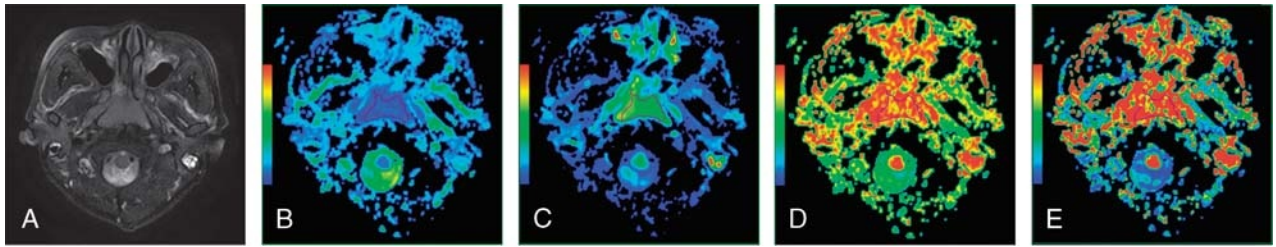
Representative images of a lymphoma. Images 2A to 2E are axial T2-weighted images, ADC, D , D^* , and f maps, respectively. The ADC, D , D^* and f values of the lesion were 0.734×10^{-3} , 0.545×10^{-3} , and 5.925×10^{-3} mm²/s, and 0.149, respectively.
